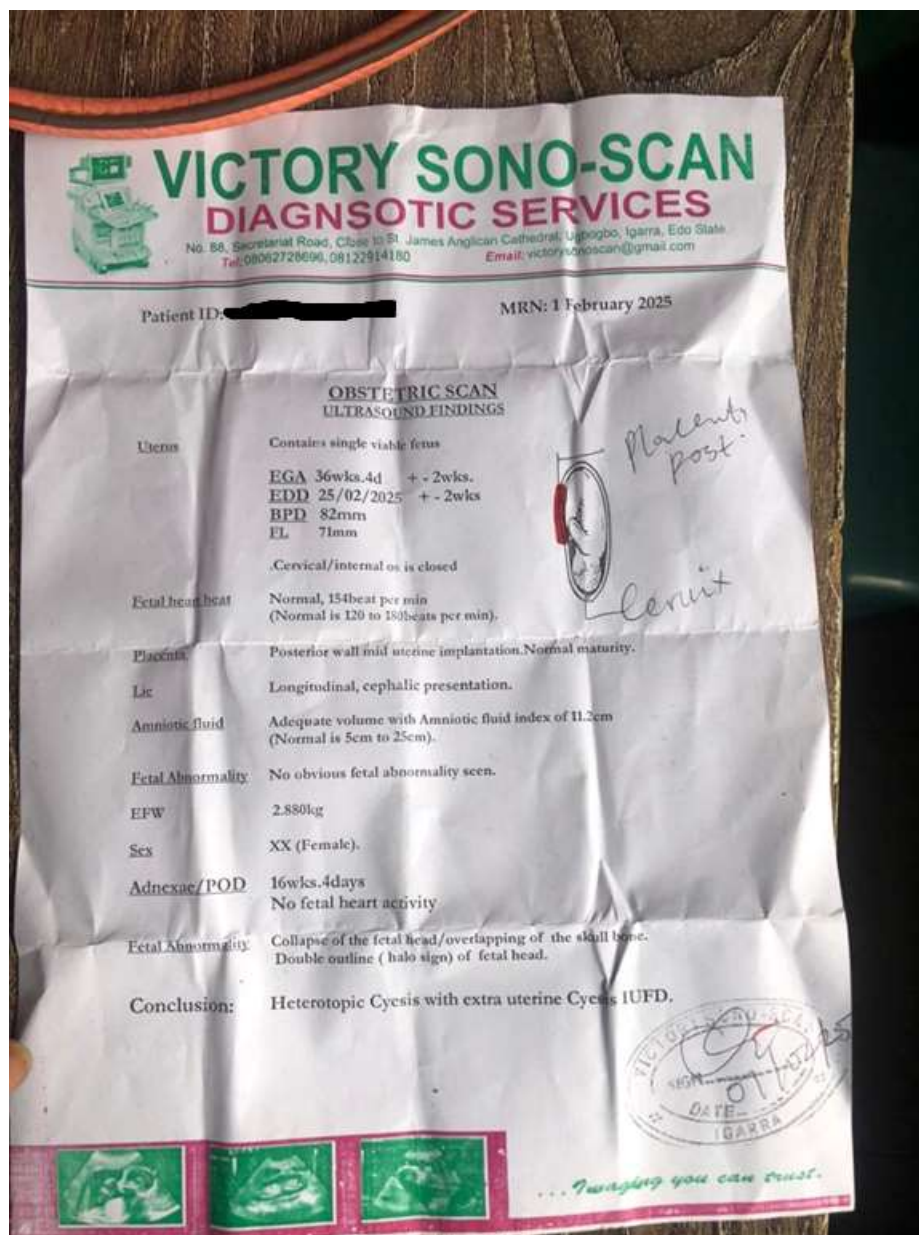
Ultrasound scan results of the study case
